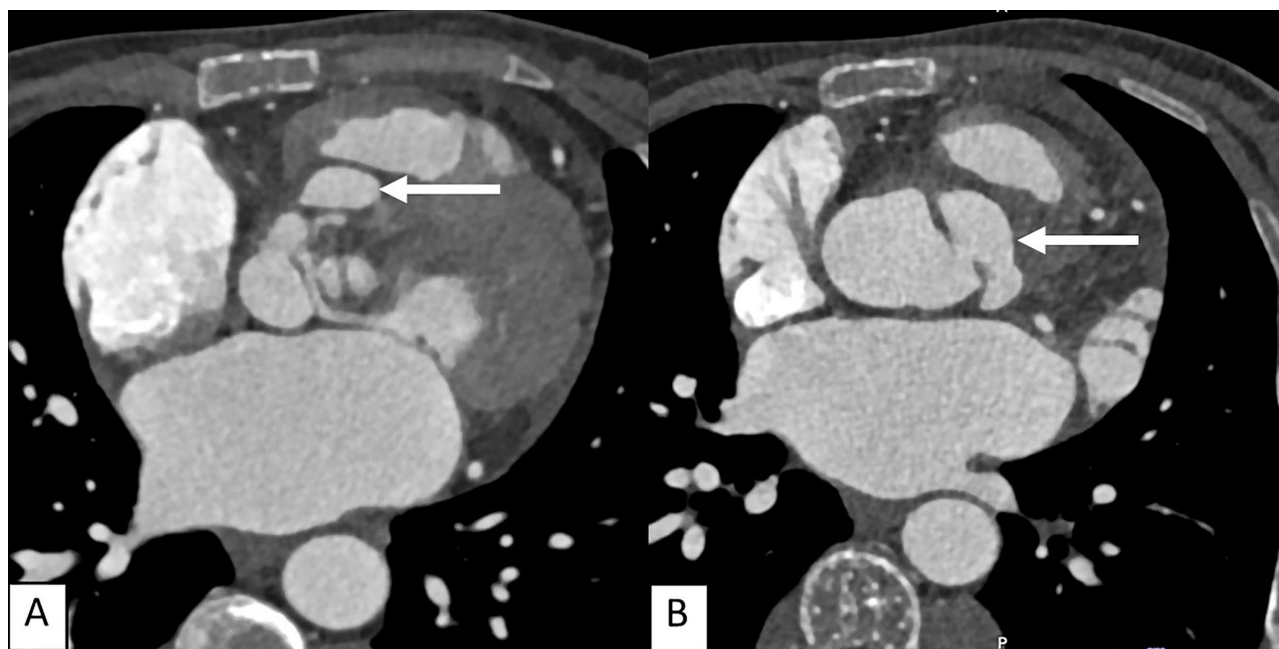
Axial view contrast-enhanced computed tomography angiography (CTA) of the heart show two small contrast-filled outpouching lesions at the right (A) and left coronary cusps (B), suggesting pseudoaneurysms.
